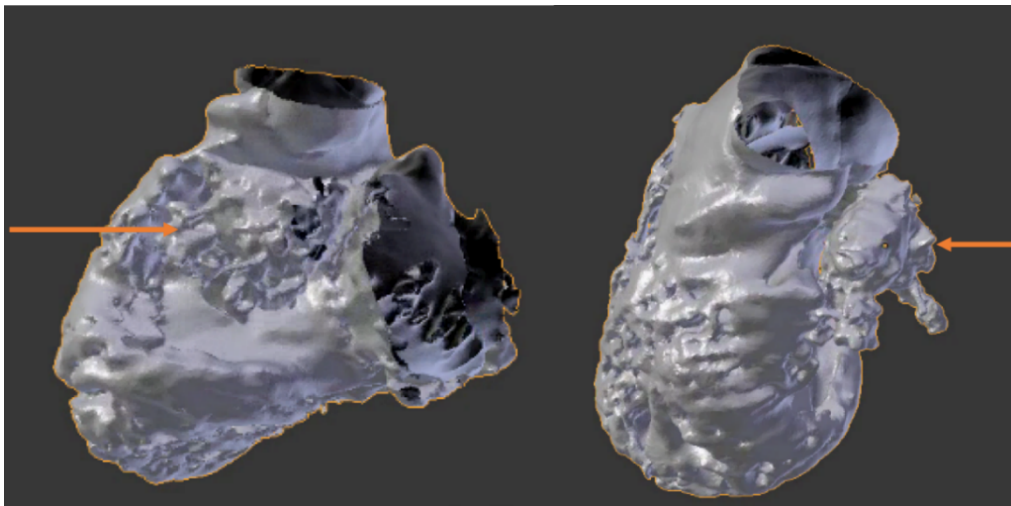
Model Created from CT Data of the Representative HLHS Post-Stage II Patient Selected for Template Creation (Orange arrow: location of LV)
